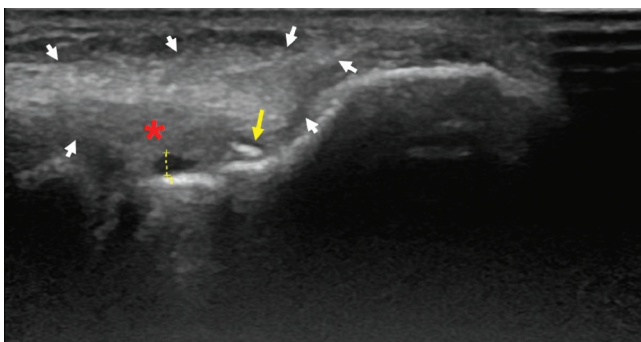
B-mode ultrasonography. Thickening on right common extensor tendon (white arrow heads), decrease in fibrillar echogenicity (red asterisk), adjacent anechoic fluid increase (dashed yellow line) and intratendinous calcification (yellow arrow).
